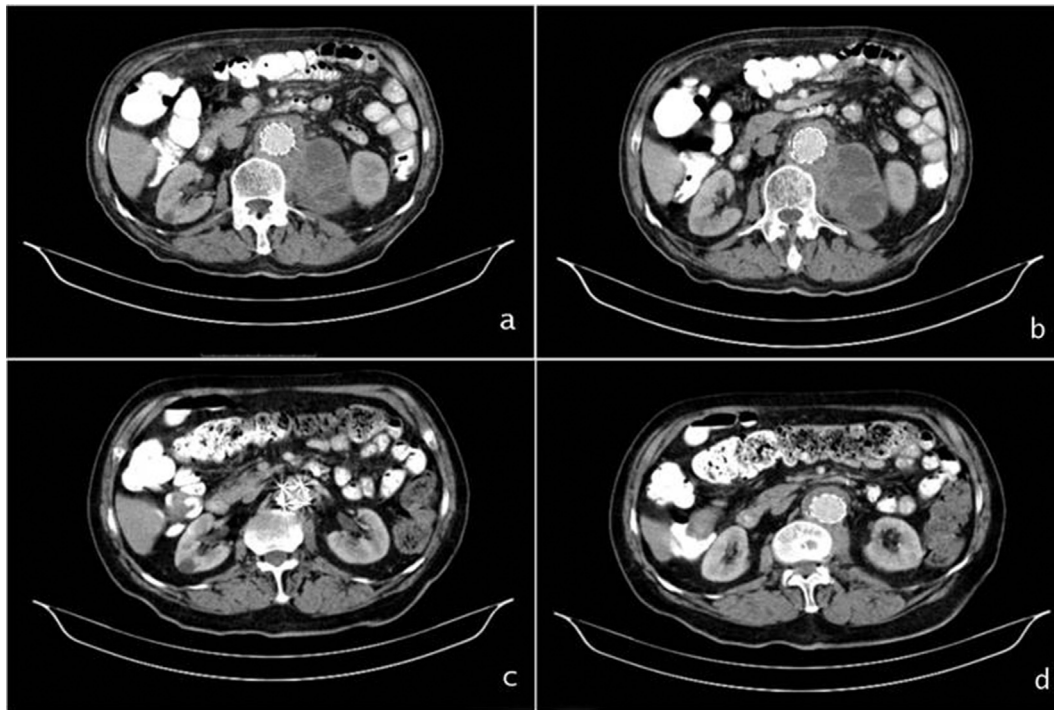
Abdominal CT showing the aortic aneurysm with an endovascular graft in it and the para-aortic mass before (a,b) and after the anti-TB treatment (c,d).
